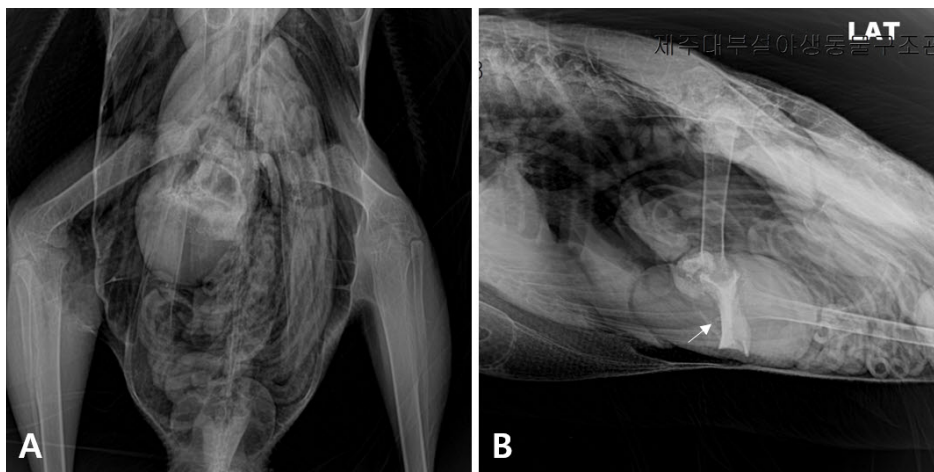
Dorsoventral view (A) and right lateral view (B) of whooper swan radiograph showing luxation of the left coxofemoral joint. The proximal of the left femur is superimposed by the gastrointestinal tract. It seems to be dislocated cranially (A). The head of the left femur is superimposed by the synsacrum and internal organs. The grit of ventriculus (arrow) (B).
